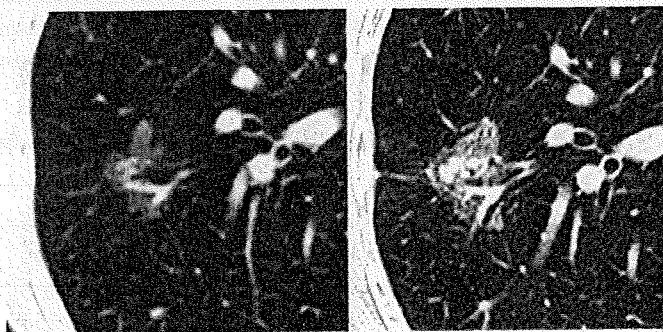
(Left: initial HRCT, right: last HRCT; type 2 radiological finding) 73-year-old female, never smoker, 11-month interval; BFWI with L858R.
